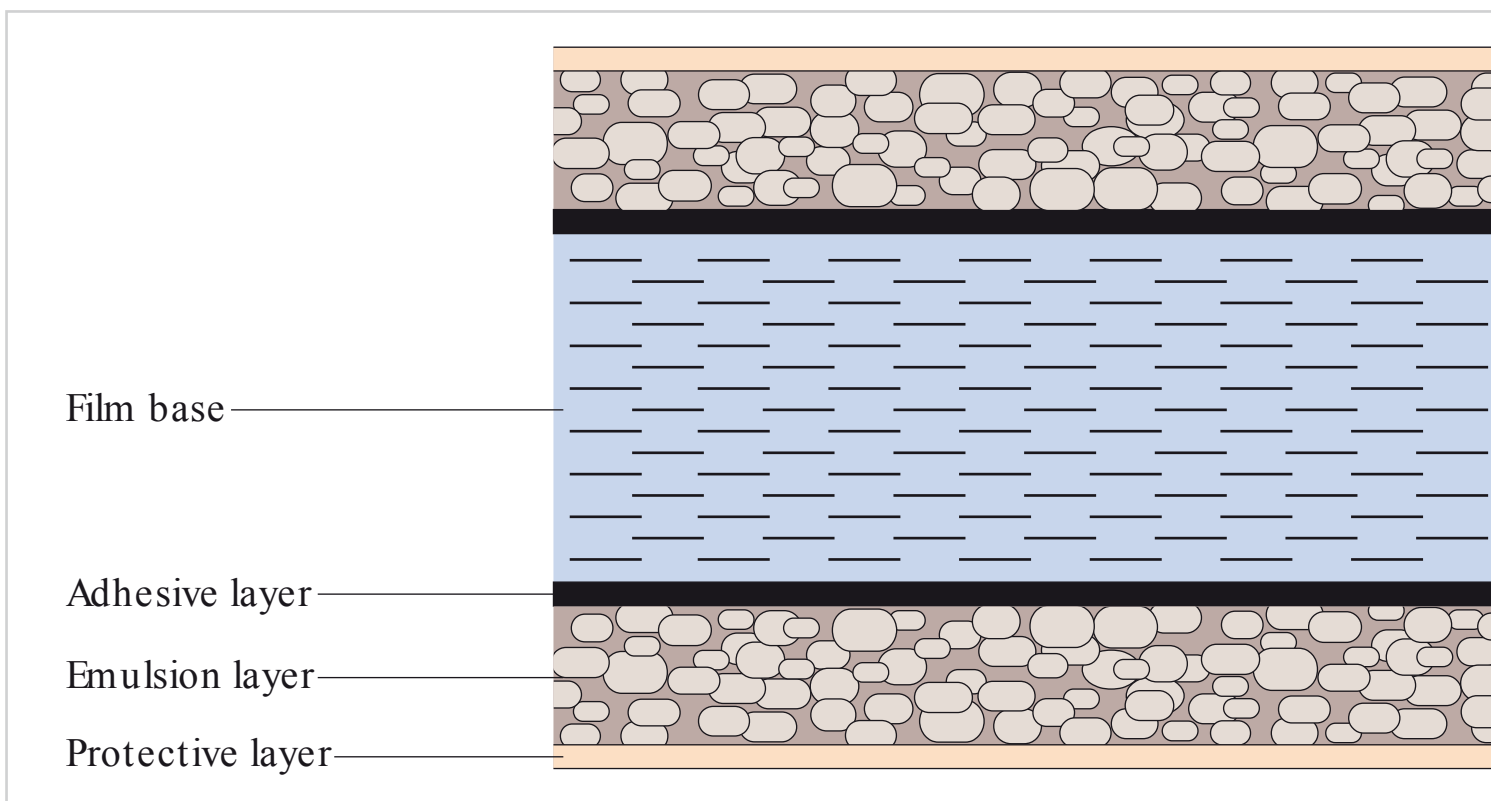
Cross-sectional structure of radiographic film.
